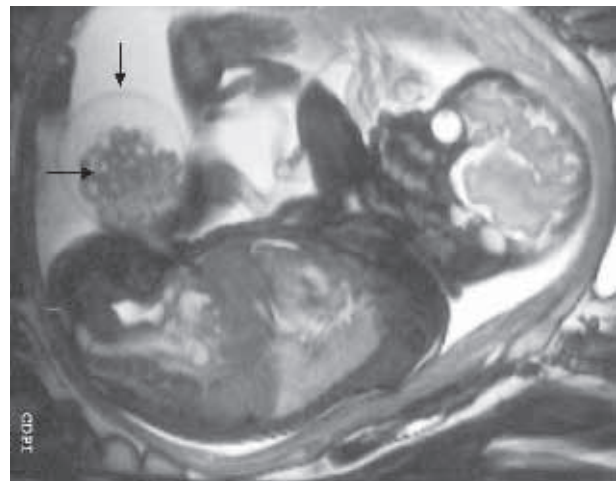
Sagittal MR image fetus with omphalocele
